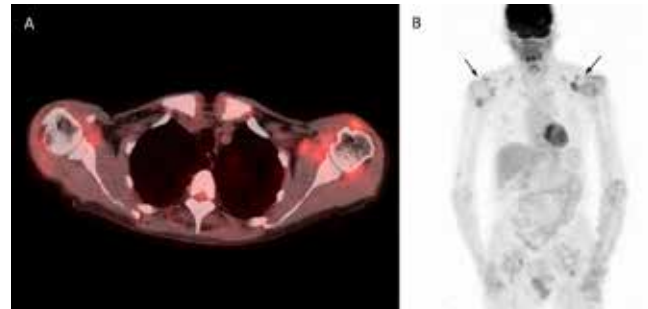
(A) Fused axial ¹⁸FDG-PET/CT image demonstrating periarticular radiotracer uptake in both shoulder joints with greater involvement on the left. (B) Coronal maximum-intensity projection ¹⁸FDG-PET/CT attenuation corrected image demonstrating FDG uptake in the periarticular regions (arrows) consistent with amyloid arthropathy.
